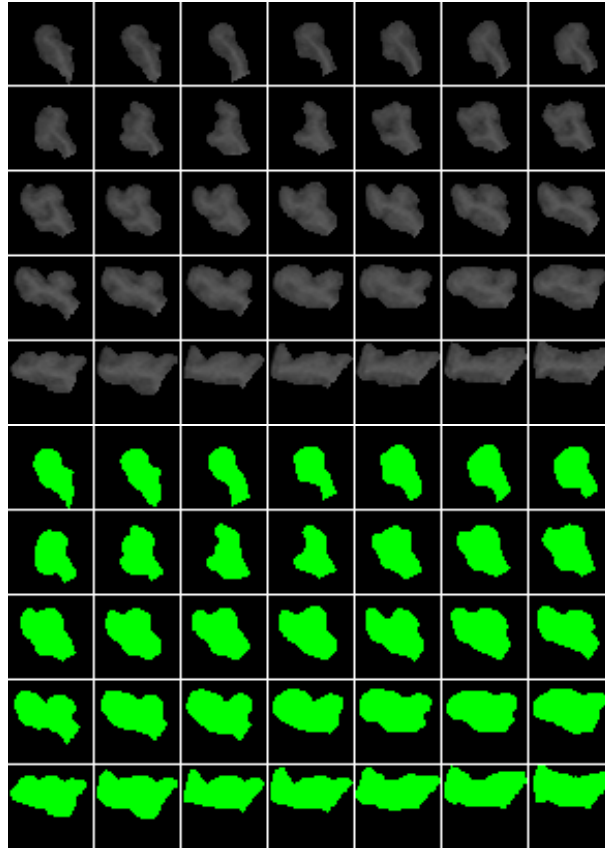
Montage of the slices in the ROI volume ($41 \times 40 \times 35$) of *r_stg* for subject 11. On the left, the MRI values; on the right, the corresponding binary masks.
